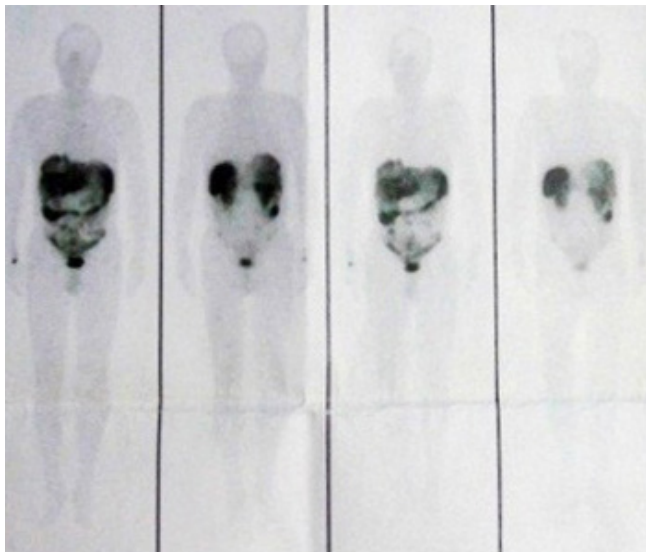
Somatostatin receptor scintigraphy (May 7, 2013).
